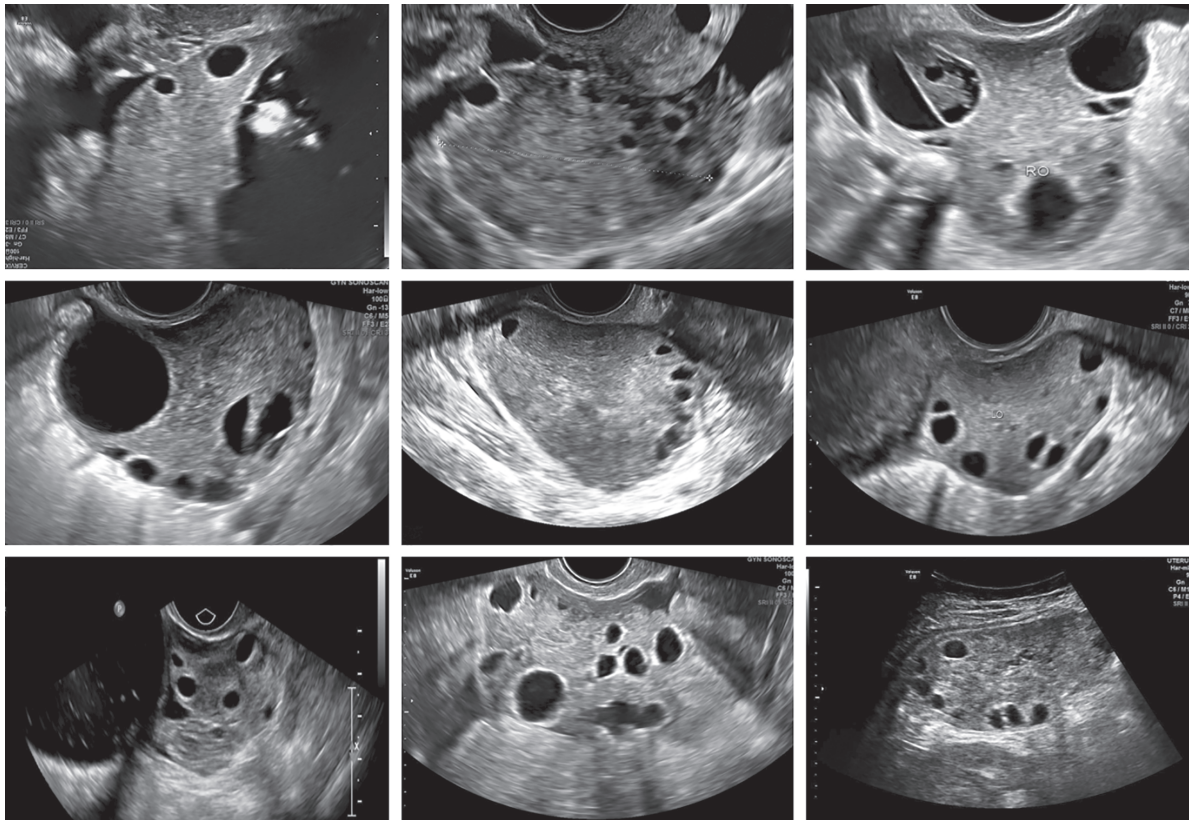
Ultrasound images of twisted adnexa manifesting follicular ring sign. LO, left ovary; RO, right ovary.
